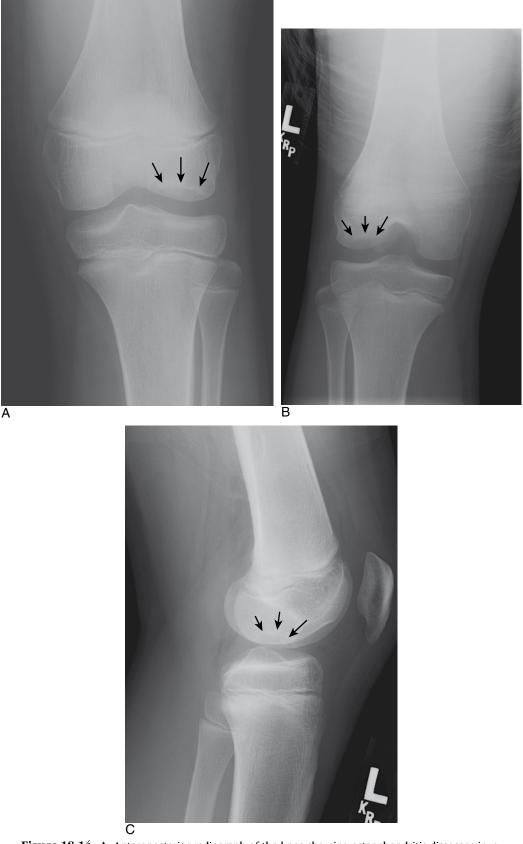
A. Anteroposterior radiograph of the knee showing osteochondritis dissecans involving the lateral femoral condyle. B. Tunnel radiograph of the same process. C. Lateral radiograph of the same process.
